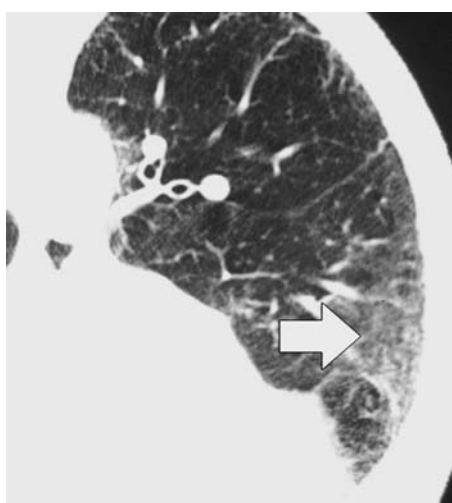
Supine thin-section computed tomography of an asbestos miner showing an area of ground glass opacity (arrow) defined as increased attenuation of the lung parenchyma without obscuration of underlying bronchovascular structures
